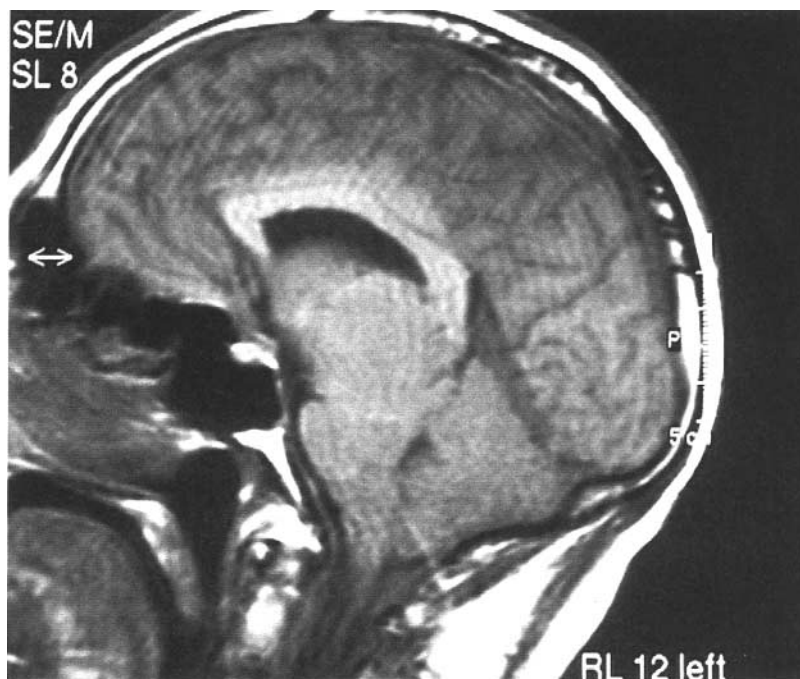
T1-weighted sagittal MR image performed after subdural hematoma drainage, showing cerebellar tonsil descent within the foramen with brainstem compression, as well as preoptine cisterna and cisterna magna disappearance
